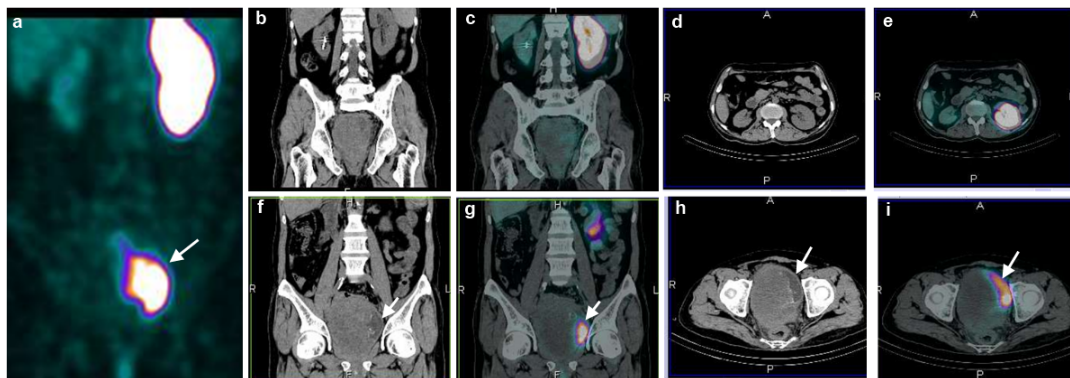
SPECT/CT and CT images (a) maximum intensity projection, (b, c, d, e) sagittal and (f, g, h, i) coronal images revealed normally located both kidneys. Right kidney was small sized and showing impaired cortical tracer uptake while left kidney was normal. Localized tracer activity in pelvis (arrow) was urinary activity in bladder which was pushed laterally, due to intra-luminal right side bladder mass.
